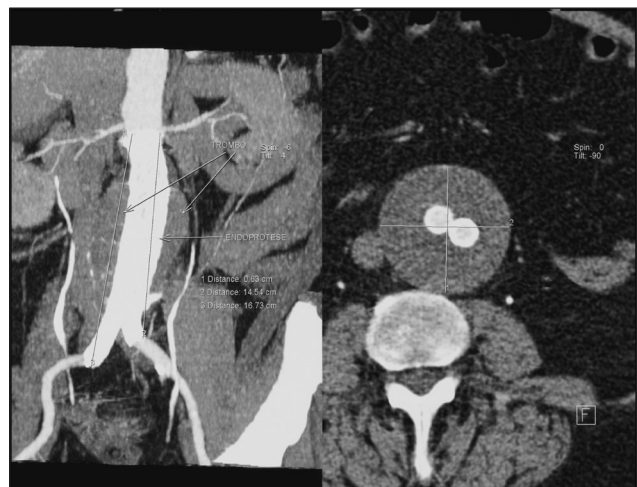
Computed tomography angiography showing increase in aneurysm sac diameter
